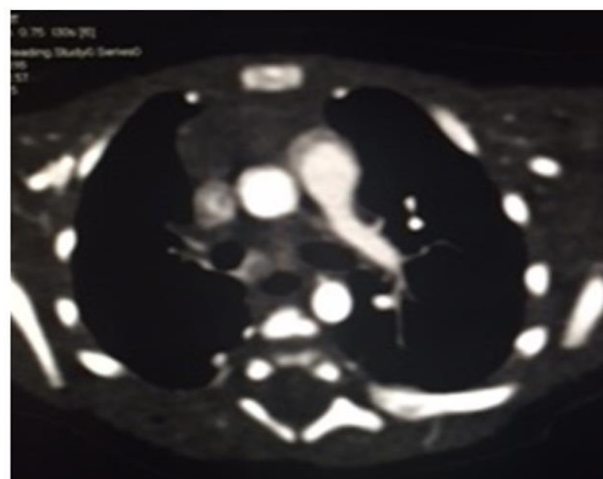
Computed Tomogram showing absent right pulmonary artery and low vascularity in the right lung.
